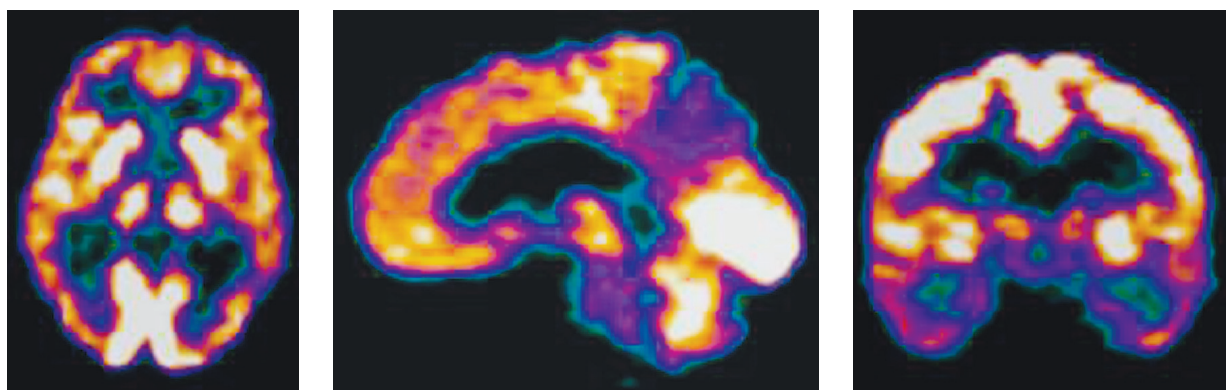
Alzheimer's disease, mild dementia: impaired accumulation of ^{18}F -FDG in the projection of the parietal, temporal lobes, hippocampus, posterior cingulate gyrus
